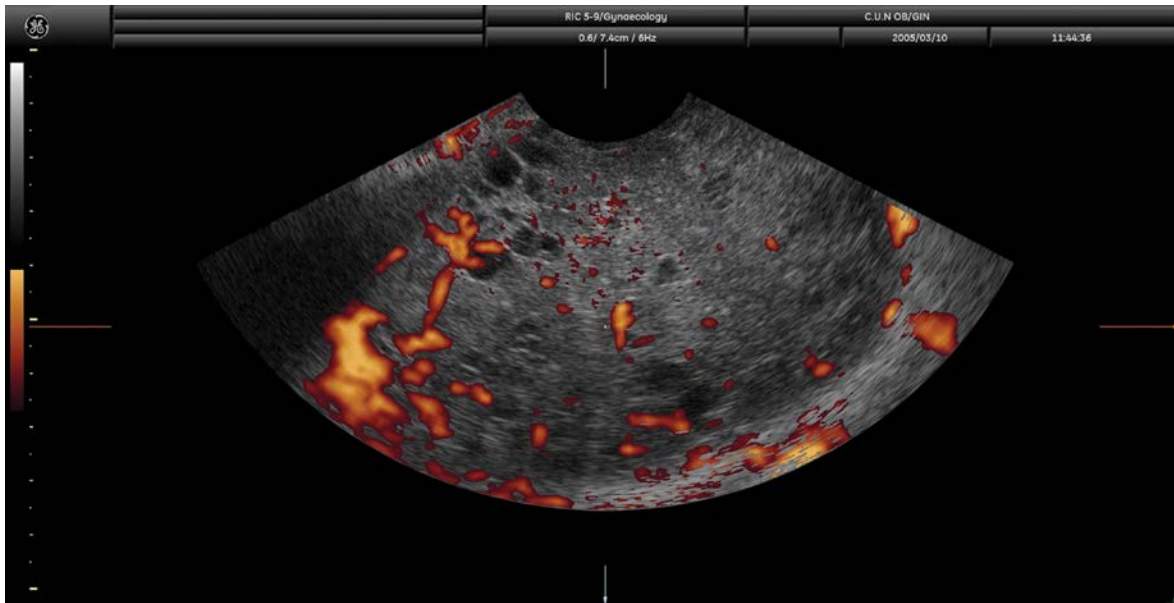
Transvaginal ultrasound from an immature teratoma in a 26-year-old woman. A solid tumor with some small cystic areas and abundant vascularization is observed.
